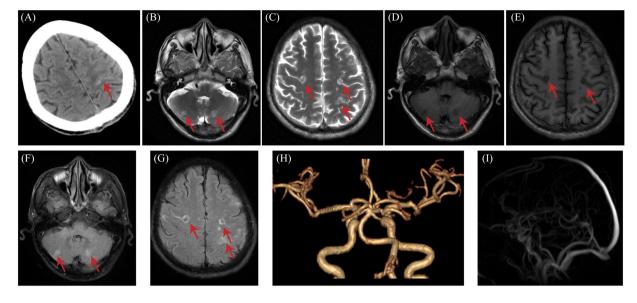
Computed tomography (CT) and magnetic resonance imaging (MRI) scan of the head. An axial CT image (Panel A) shows a suspicious high-density shadow in the left parietal lobe brain sulcus (red arrow). An axial MRI T2-weighted image (Panels B and C) shows multiple and diffuse high signals in the cerebellum and parietal lobe (red arrow). An axial MRI T1-weighted image (Panels D and E) shows multiple and diffuse low signals in the cerebellum and parietal lobe. An axial MRI fluid-attenuated inversion recovery sequence (Panels F and G) shows multiple and diffuse high signals in the cerebellum and parietal lobe. Magnetic resonance angiography (Panel H) indicates absence of large intracranial vessel occlusion. Magnetic resonance venography (Panel I) shows a normal intracranial venous system.
